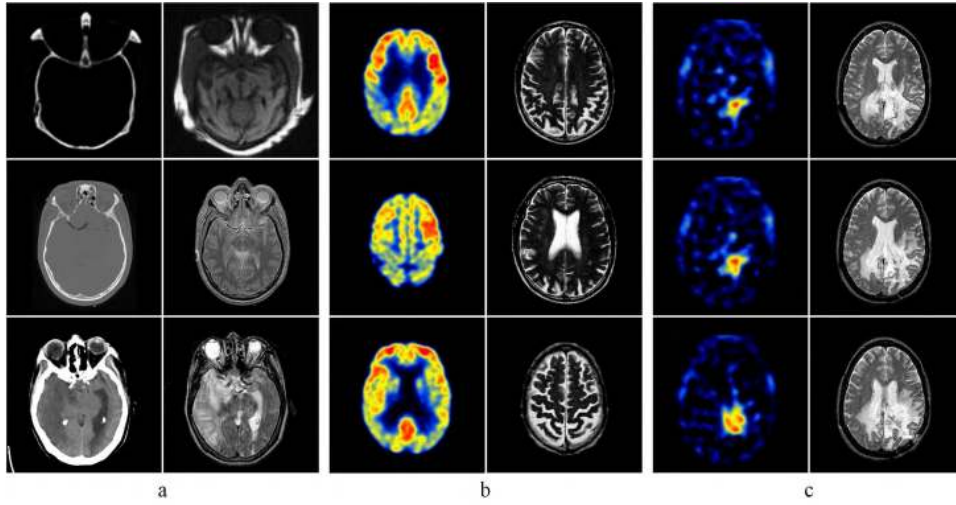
Source images of comparative experiments. (a), (b), and (c) are CT-MRI, MRI-PET, and SPECT-MRI source image pairs respectively.
